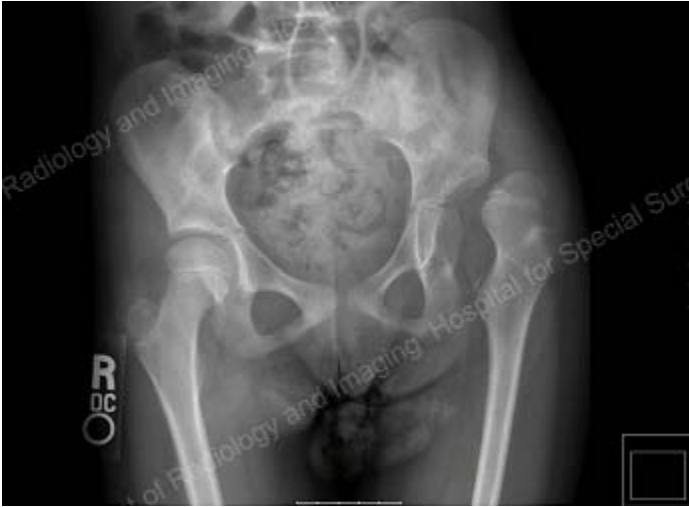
AP x-ray demonstrating a dysplastic, dislocated left hip and coxa valga (abnormal alignment) of the right hip.
